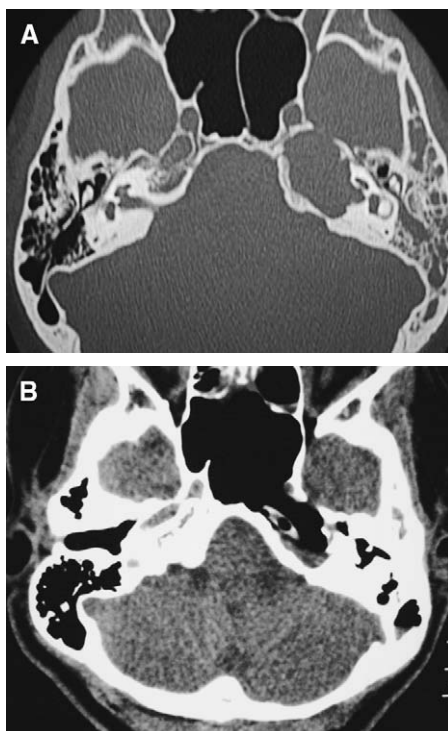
(A) Axial CT of a cholesterol granuloma of the petrous apex. (The patient presented with left cranial nerve VII paralysis and left mixed hearing loss). (B) Postoperative CT of the same patient shown in Fig. 8A. (Note the apical communication into sphenoid sinus and presence of drainage catheter.)
